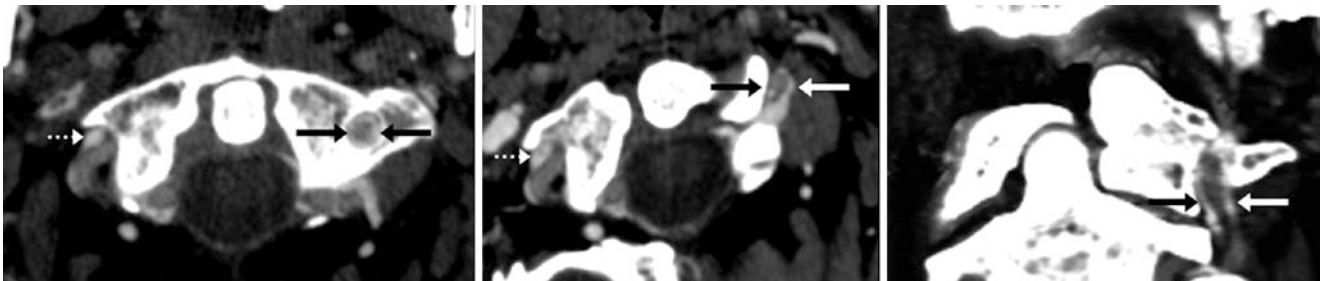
In this 60-year-old, a CTA that was partially in the venous phase demonstrates a left VVP surrounding the VA (*arrows*) on axial (*left and middle*) and coronal (*right*) MPRs. The right VVP appears to be a single vein (*dotted arrows*)
